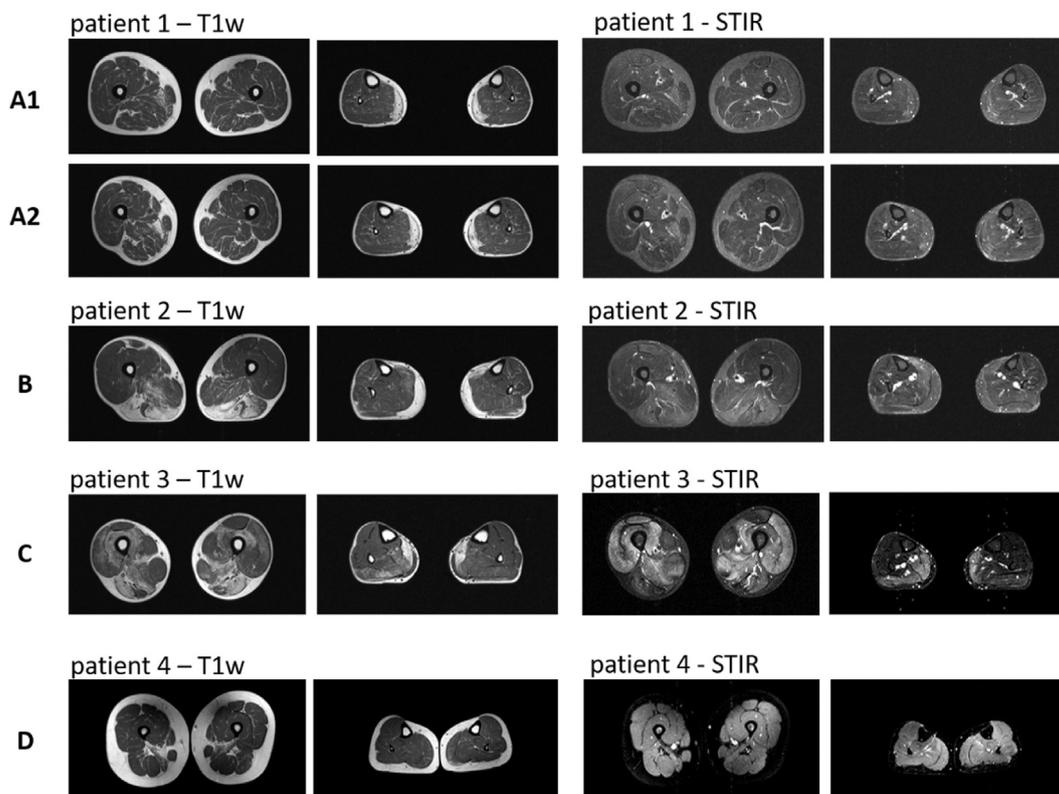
Skeletal muscle MRI of 4 *ANO5*-patients (A–D). The two left panels show fatty degeneration in T1w-sequences, the two right panels display tissue edema in the STIR-sequences. Patient 1 (A1 and A2) has been investigated twice: at the time of first presentation (A1) and at follow-up after 10 years (A2). From each patient, representative images of thighs (left image in panel) and calves (right image in panel) were chosen. STIR: short-tau-inversion-recovery-sequence.
